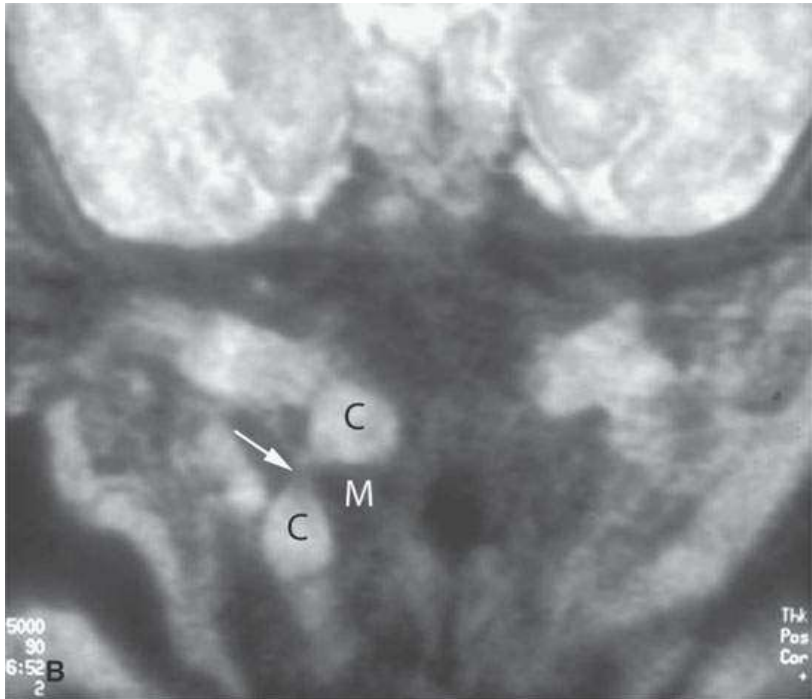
Magnetic resonance imaging of an infant with a pharyngeal wall mass. In both the T-weighted (A) and T2-weighted (B) images, the cystic structure (C) can be seen. Its appearance as it crosses the muscular (M) pharyngeal wall (*arrow*) to extend from the pharynx into the neck is an anatomic pattern unmistakably recognizable as a branchial apparatus anomaly, even though this particular type of cyst is rare.
